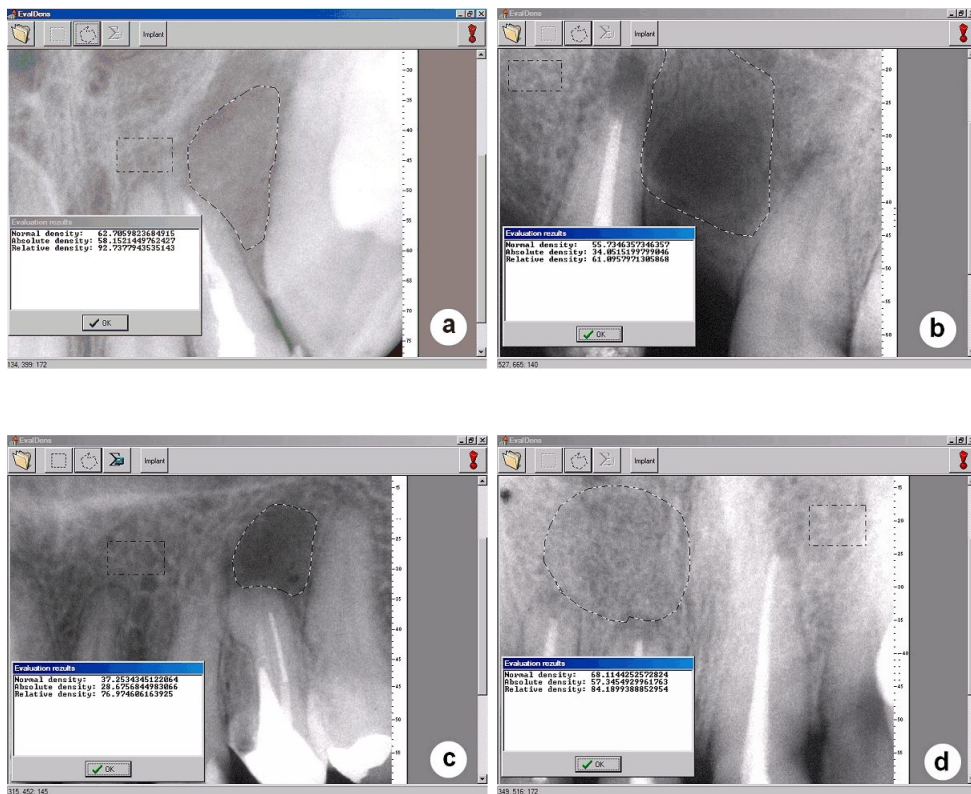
(a-d) Application of the EvalDens densitometric analysis to assess the relative density of four apical defects treated with Osteoinductal; rectangular area = the standard reference area of sound periapical bone; irregular area = area of the previous lesion treated with Osteoinductal
